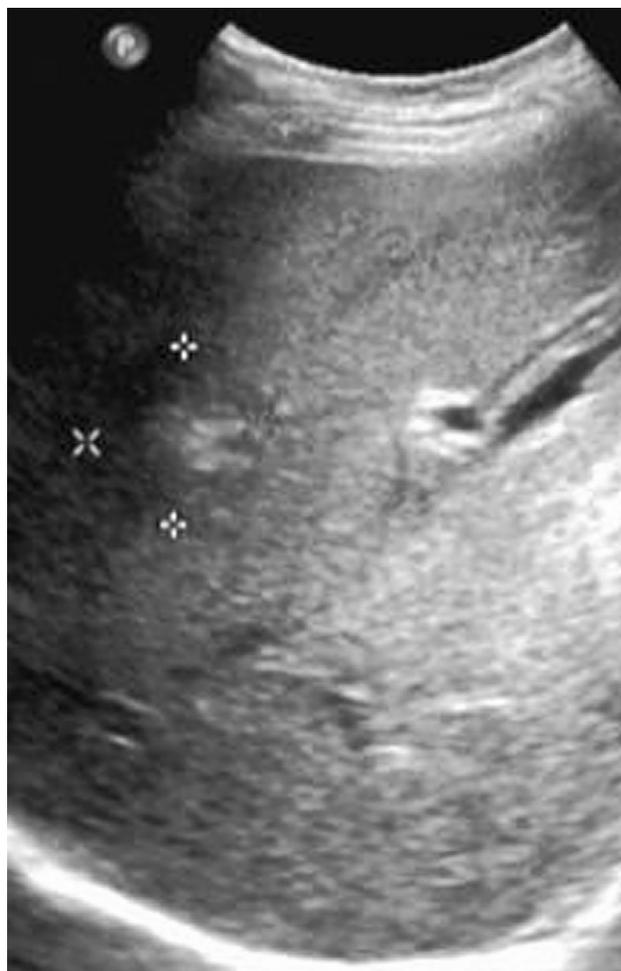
Sequential abdominal sonogram two and a half months after the initial imaging studies seen in Fig. 1 showed a residual mixed echoic lesion measuring 2.6 cm × 2.8 cm.
